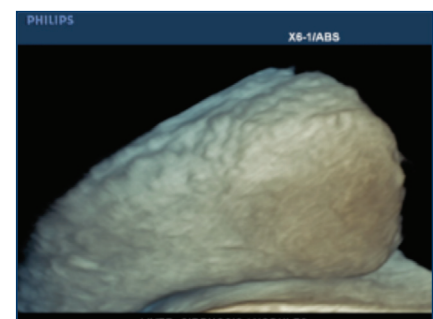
Ultrasound volume image of a cirrhotic liver with surface nodules.
